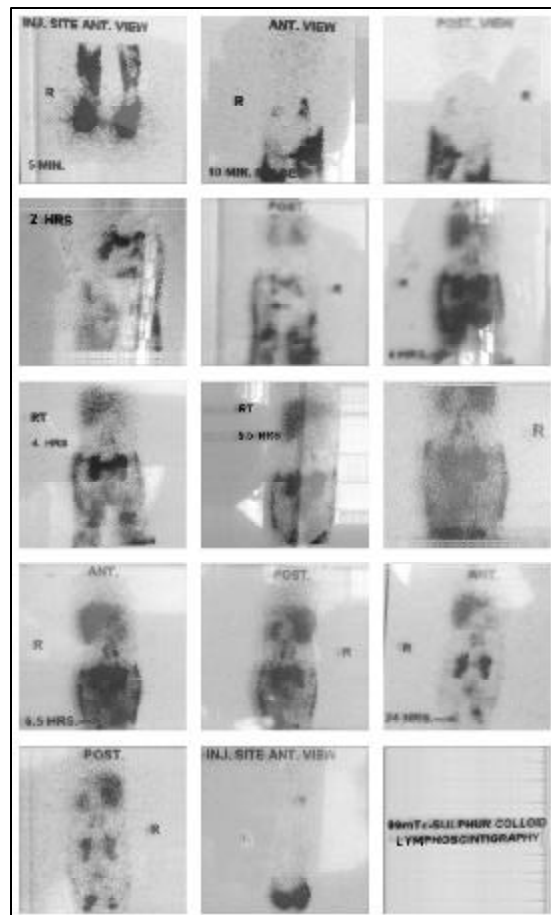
Showing lymphoscintigraphy showing a) lymphatic distal to external iliac nodes are atretic; b) external iliac nodes are normal; c) lymphatics above external iliac nodes are normal.
